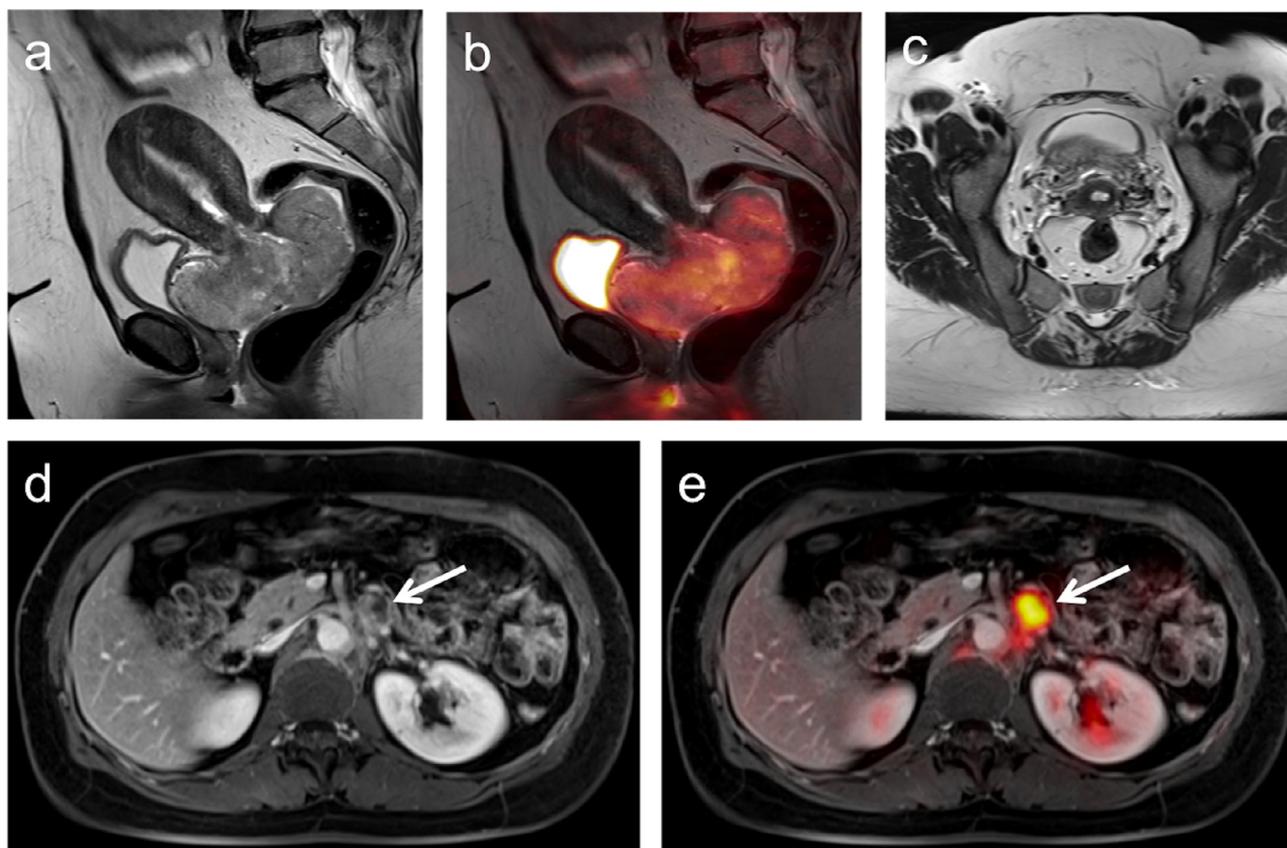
Images of a 43-year-old patient with an exophytic growing cervical cancer (a, T2w) with pathologically increased glucose metabolism (b, PET/MRI). No parametrial tumor invasion was detected (c, T2w). Whole-body MR (d, contrast-enhanced T1w) and PET/MR (e) images reveal an enlarged ^{18}F -FDG-PET-positive para-aortic lymph node metastasis.
